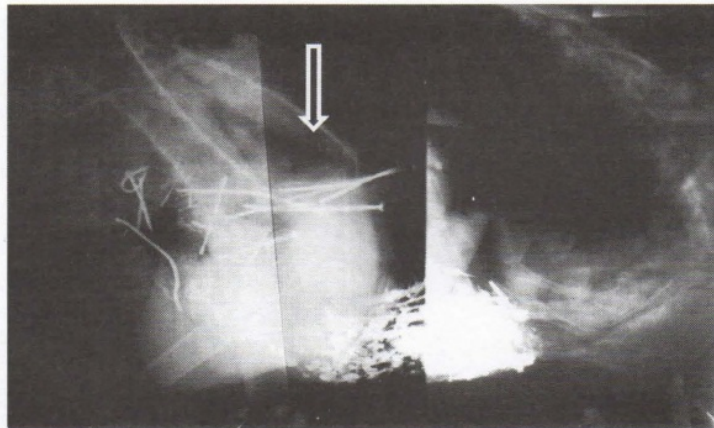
The abdominal position of the foreign body in the case seen on lateral X-ray (arrow)
